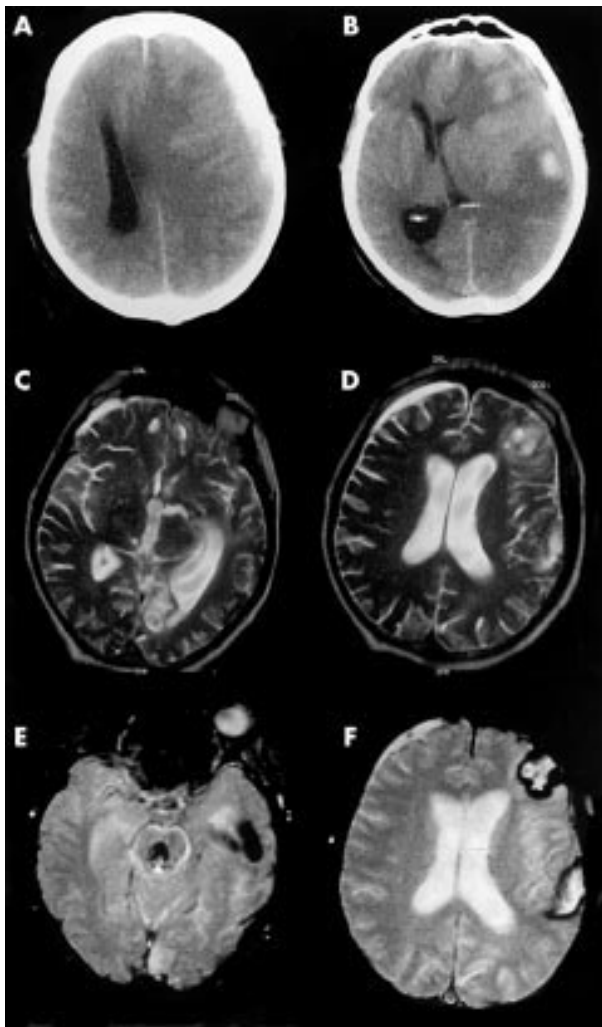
Thirty four year old man: deteriorated over seven days after a fall before presenting unconscious. Initial CT head scan shows mixed density subdural containing isodense and hyperdense components (A), and (B) cerebral contusions in the left frontal and temporal lobes, left hemisphere swelling, pronounced midline shift, and left uncus herniation; there is also evidence of left posterior cerebral artery (PCA) territory ischaemia and contralateral hydrocephalus. MRI six weeks later shows a shallow right frontal subdural collection, the left hemisphere swelling has resolved, the left PCA infarct has matured, and there are additional signs of residual damage in the frontal lobes, right thalamus, and left inferior anterior capsule (C, D). A T2 gradient echo sequence demonstrates the previous contusions (F) and the presence of blood breakdown products in the midbrain following haemorrhagic midbrain (E) infarction caused by transtentorial herniation. The low signal intensity in the left mid-temporal region is caused by partial volume of the petrous bone.
